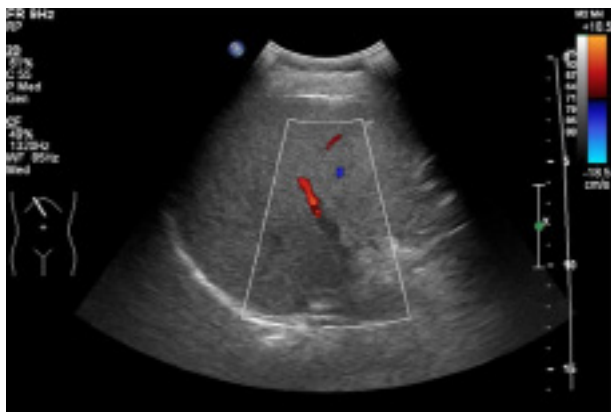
Ultrasound sonography imaging of the liver.
